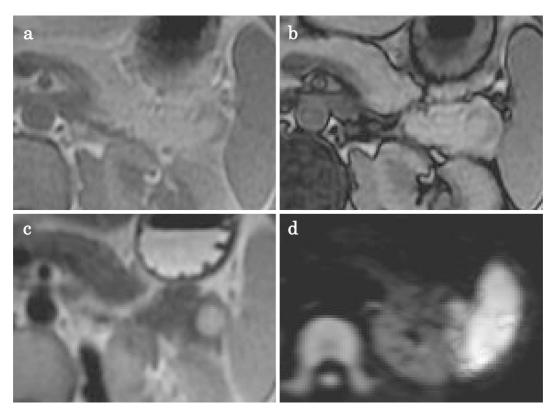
Magnetic resonance images reveal that the intensity of the solid component on T1 weighted image and T2 weighted image is closely similar to that of the spleen and different from that of the pancreatic parenchyma (a: T1WI in phase, b: T1WI out of phase, c: T2WI, d: Diffusion WI).
